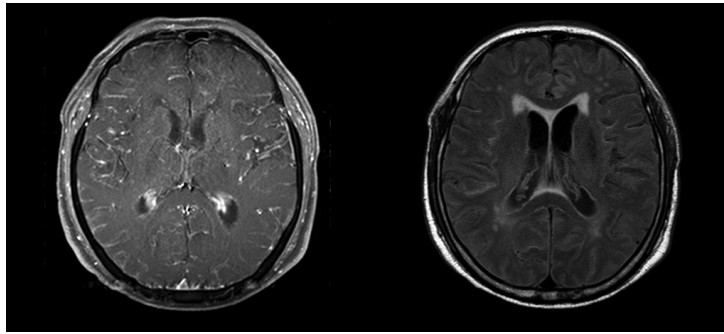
Initial brain MRI of the patient. (Left) Axial T1-weighted gadolinium-enhance image showed profound meningeal enhancement. (Right) FLAIR image showed minimal degree hydrocephalus suspected with white matter change by interstitial edema at the bilateral horns of lateral ventricles.
